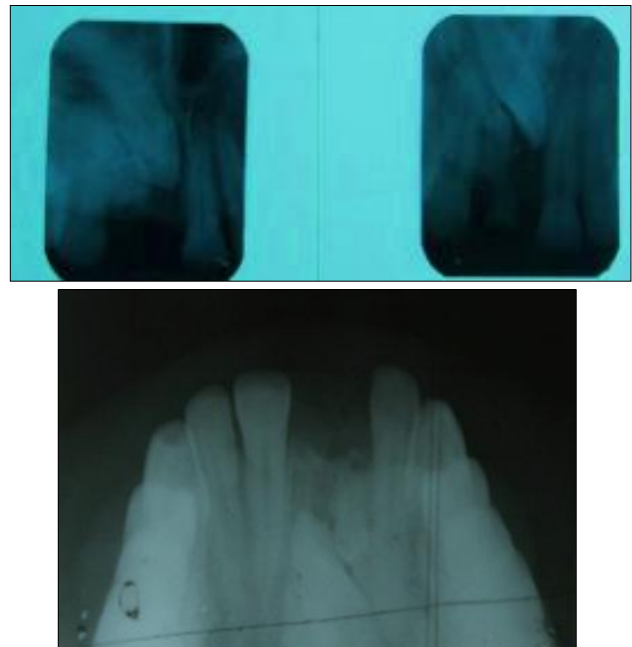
Pre treatment intraoral periapical and occlusal radiographs
